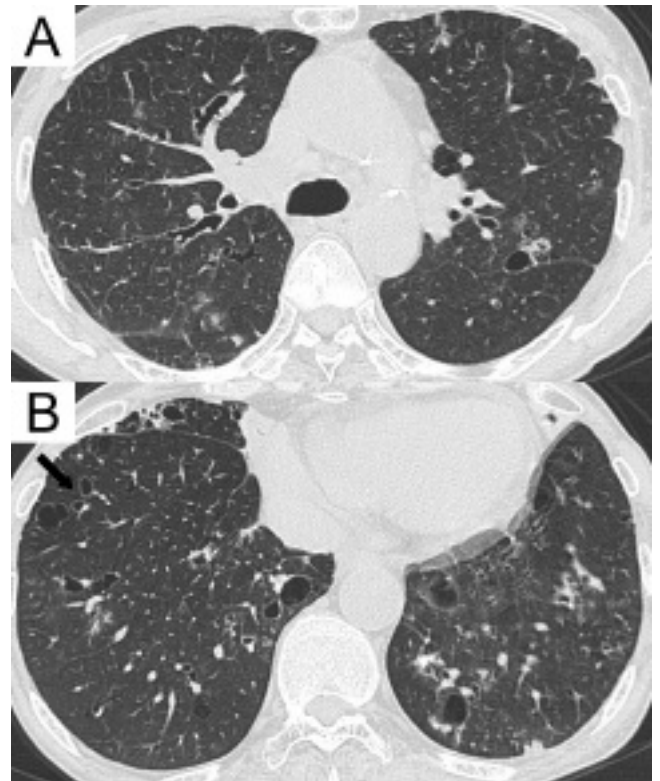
A 68-year-old woman with primary Sjögren's syndrome with anti-SSB/La, accompanied by mixed-type cryoglobulinemia and mucosa-associated lymphoid tissue lymphoma in the trachea. Thin-section CT scans at the level of carina (A) and 2 cm above the lung dome (B) show bronchiectasis, bronchiolectasis, thin-walled lung cysts, ill-defined centrilobular nodules, interlobular septal thickening, and patchy ground-glass opacities. Note dilated bronchioles adjacent to a cystic space (arrow).
